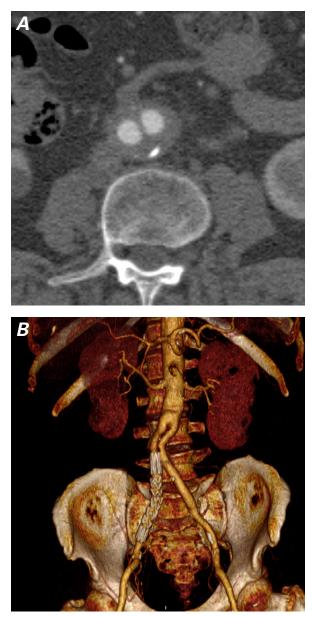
At the 3-year follow-up evaluation, computed tomographic angiograms show A) no evidence of recurrent infection (axial view), and B) good graft patency and correct positioning of the right iliac stent-graft (volume-rendered 3-dimensional reconstruction).
